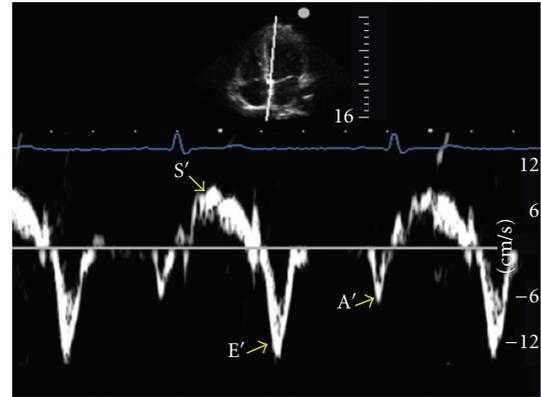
Spectral tissue Doppler tracing for the apical 4-chamber transthoracic window, showing the cursor position on the septal basal segment. The transducer is placed at the apex of the heart and angled towards the head.
